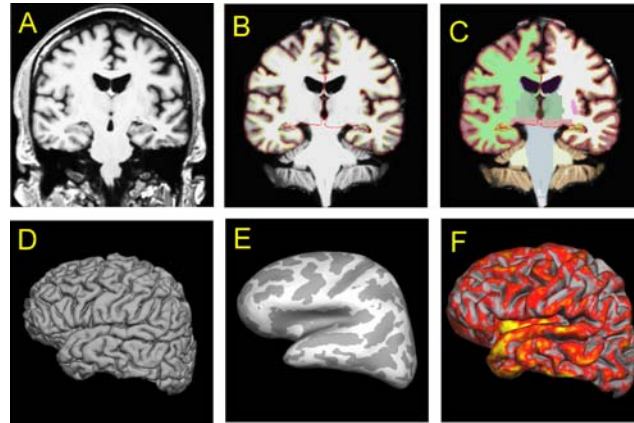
Surface and volume segmentation in Freesurfer. Sample figures from different steps in the Freesurfer segmentation process of a T1-weighted MP-RAGE volume from a middle aged healthy male enrolled in one of our studies. (A) Two MP-RAGE volumes averaged, intensity normalized and corrected for motion artifacts. (B) A skulled stripped and surface segmented version of the same volume. The red line represents the brain surface, and the yellow line the border between grey and white matter. The distance between these lines represents the cortical thickness at every point in the cortical mantle. (C) Automatic subcortical segmentation. The colors depict different structures. (D) A lateral view of the digital reconstruction of the surface of the left hemisphere. (E) An inflated representation of the same hemisphere. The dark grey areas represents sulci. (F) A thickness map overlaid a semi inflated representation the same hemisphere. Grey: 0-2 mm, red: 2-3,5 mm, yellow: 3,5-4,5 mm thickness of the cortical surface.
